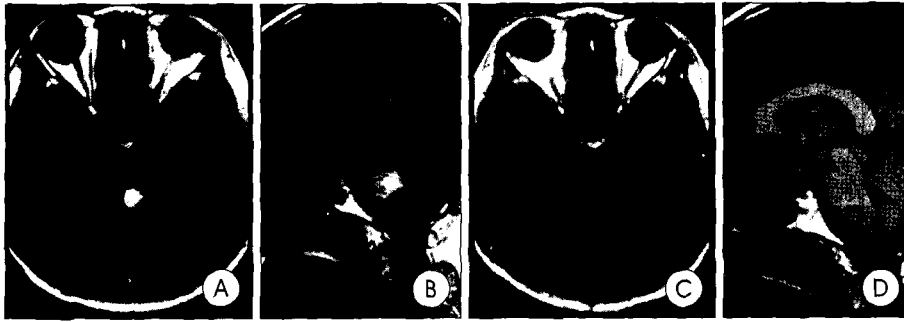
Case 11. A 33-year-old woman presented with right sided weakness and headache. Preoperative T1-weighted axial (A) and sagittal (B) magnetic resonance images reveal a pontine cavernous hemangioma. The patient underwent a midline suboccipital approach to remove the cavernous hemangioma and experienced significant improvement in her preoperative symptoms. Postoperative images (C, D) indicate complete resection of the lesion.
